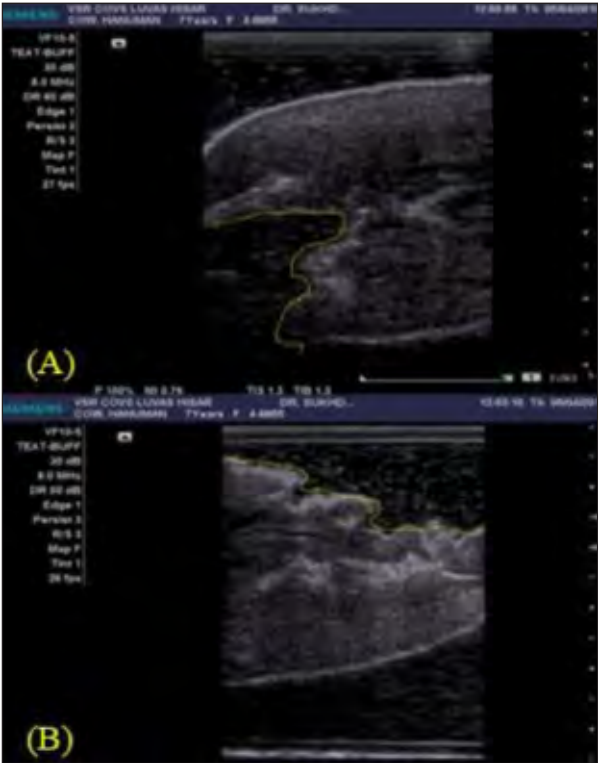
(A, B). Ultrasonographic image of damage and loss of tissue of teat shown due to teat fistula (Water bath technique; vertical scan; 8MHz linear probe)
